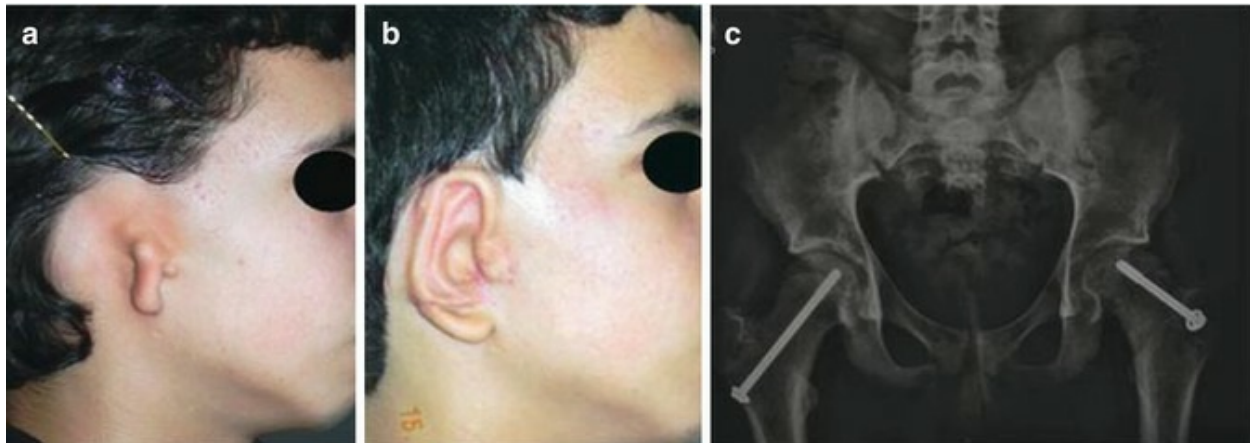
Complex associated anomalies on two patients with anotia. (a) Pre-operative photo of a 19-year-old male patient with anotia on the right side. He presented with bilateral congenital dislocation of the hip. (b) Post-operative photo after the first stage of ear reconstruction using rib cartilage to excavate the new auricular framework. (c) Radiograph after orthopedic treatment. He also presented with a complex anomaly of the face, optic nerves, and polydactyl on his left hand
